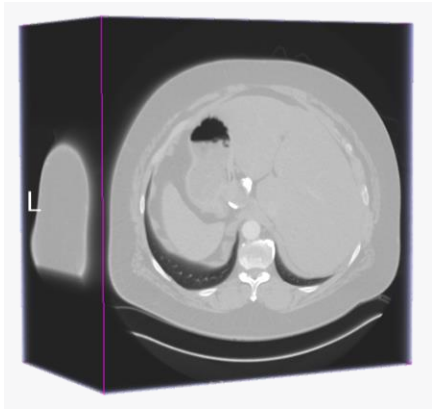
A patient's original abdominal CT image
